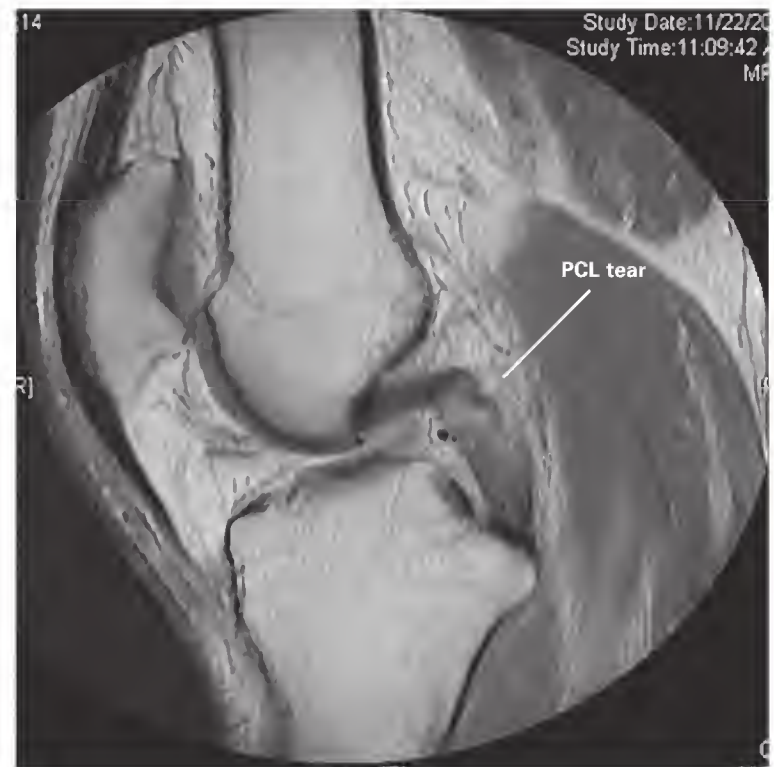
Magnetic resonance image showing rupture of the posterior cruciate ligament (PCL).
